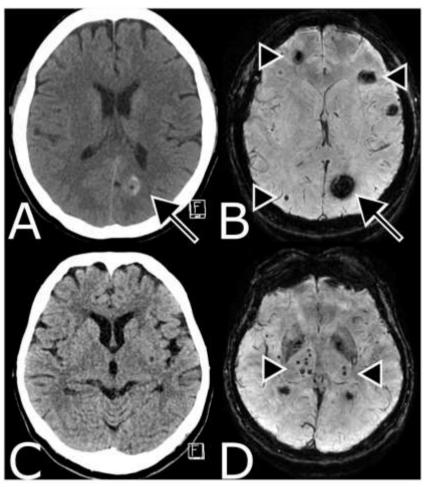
Two cases with unique and useful NeuroMix information on SWI. A-B) 49-year-old female presenting with worsening multifocal pain, weakness and numbness not confined to a particular neurovascular territory. A) Axial non-contrast CT head shows a heterogeneously hyperattenuating lesion in the left parieto-occipital white matter (arrow). B) Axial NeuroMix SWI shows blooming of this lesion (arrow) as well as multiple lesions not evident on CT (arrowheads), consistent with multiple cavernous vascular malformations. C-D) 74-year-old female with transient left facial droop and dysarthria. C) Axial non-contrast CT without significant structural abnormality. D) Axial NeuroMix SWI shows central-predominant foci of susceptibility (arrowheads) suspicious for hypertensive microhemorrhages.
